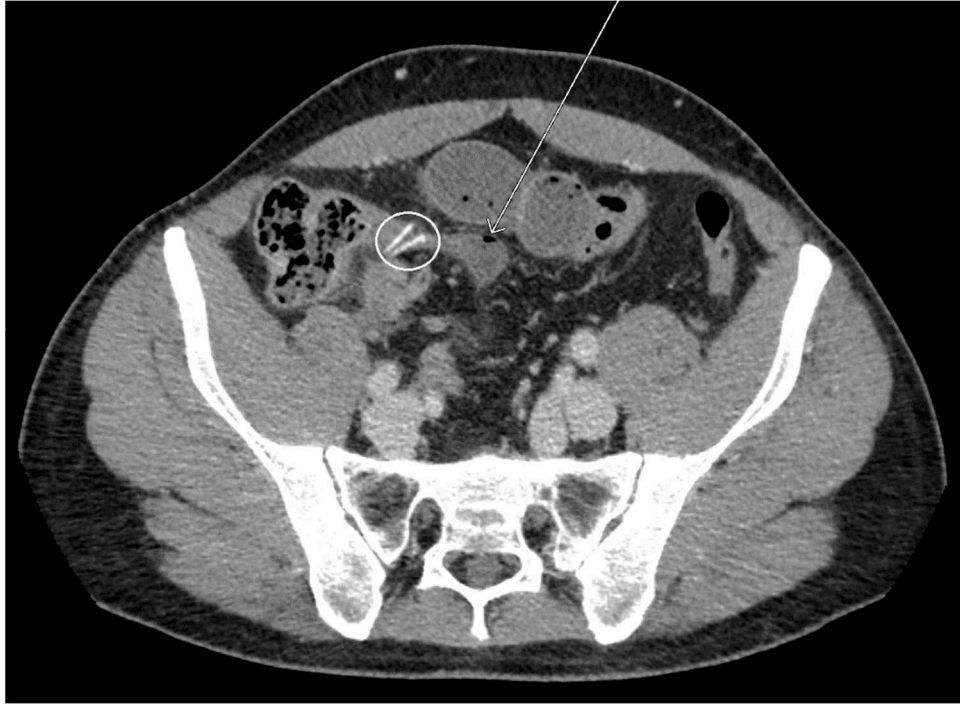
CT scan: MD (arrow) and suturing clips of previous appendectomy (circle).
